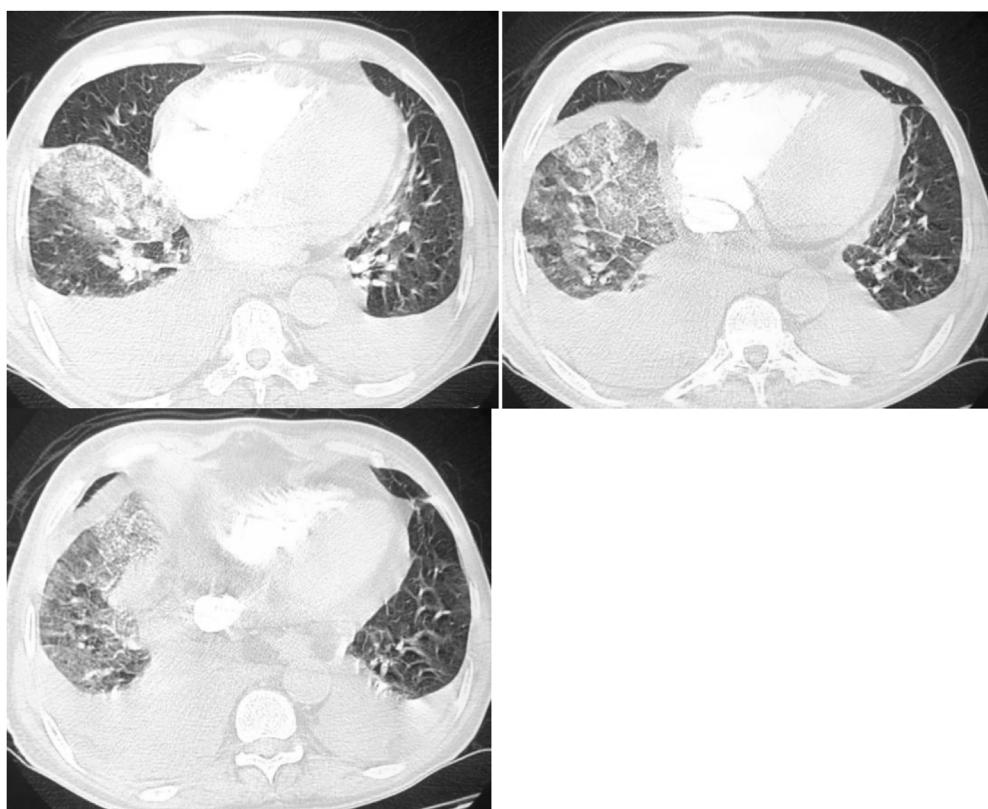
Axial CT scan (lung window) of the chest shows lung damage and involvement due to the coronavirus such as right basal ground-glass opacities associated with crazy paving appearance, in addition to bilateral pleural effusions.
